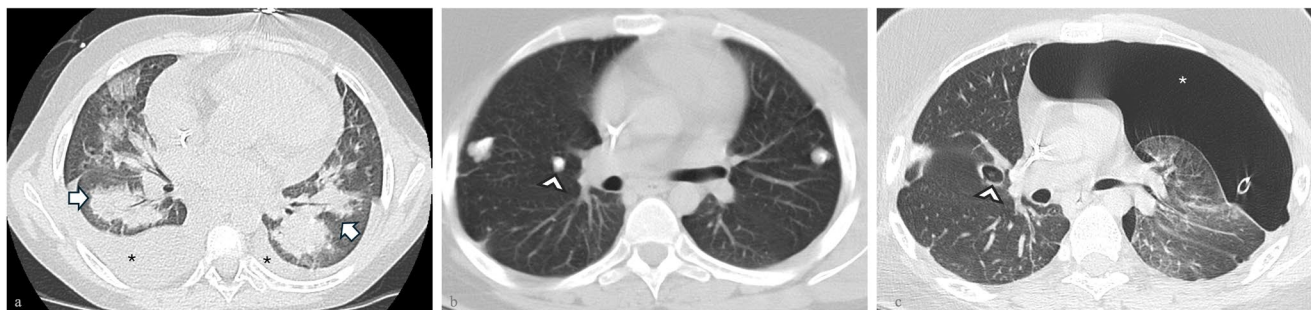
In a, axial chest CT image demonstrating bilateral para-hilar consolidations (white arrows) and pleural effusion (black asterisks) in an eleven-year-old girl with B-cell acute lymphoblastic leukemia who shortly after hematopoietic stem cell transplantation developed cough and fever. The findings were suggestive of idiopathic pneumonia syndrome; no clinical or laboratory signs of infection were detected. In b
